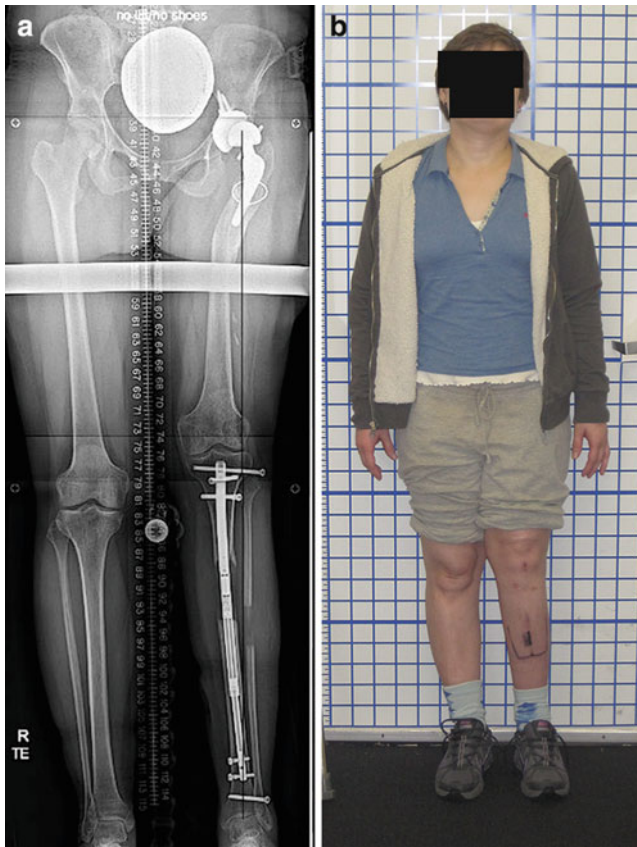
(a) Bipedal standing X-ray at end of distraction (70 days after surgery) showing equal leg lengths. Note MAD position relative to preoperative (Fig. 1a). Mild increase in valgus did occur. (b) Front view at 3 months showing equal leg lengths. Note the *mark* on skin for EMC placement
